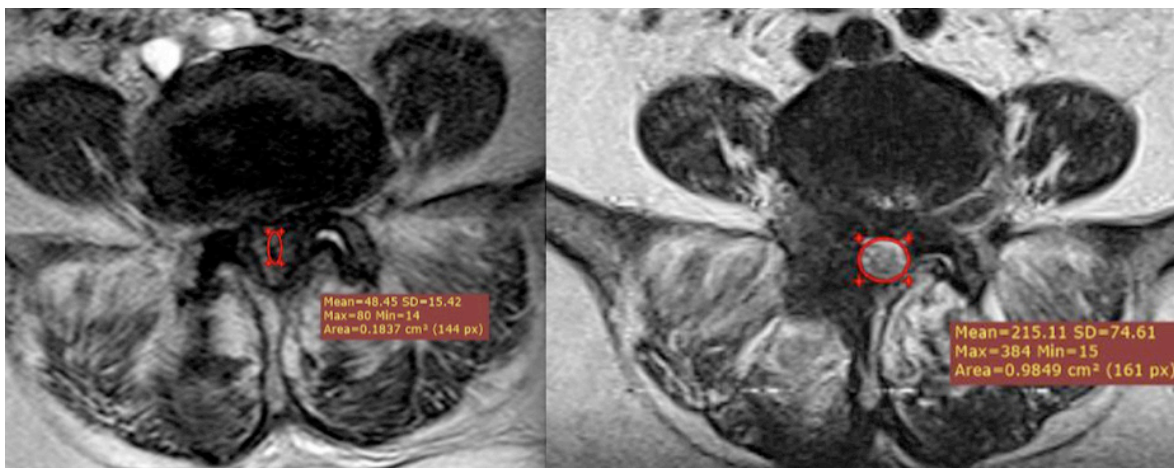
Spinal canal cross-sectional area on preoperative and postoperative MRI.
